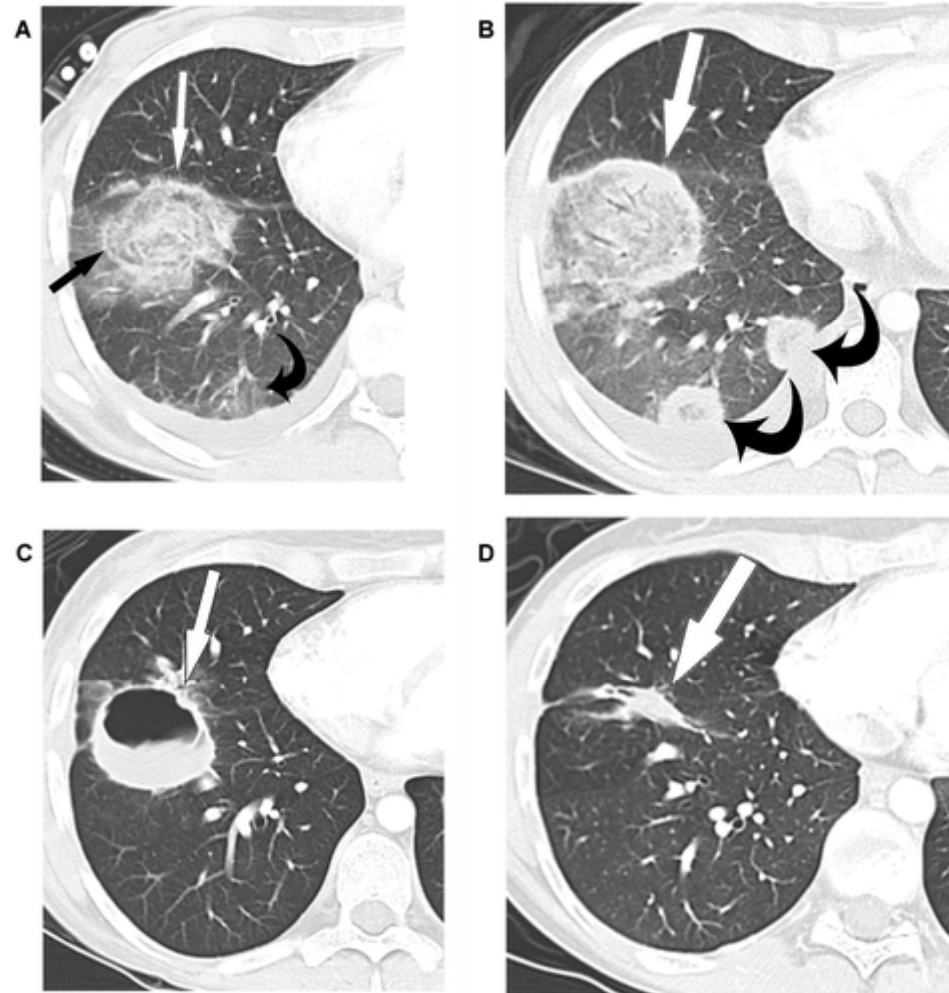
Images from a 24-year-old woman who presented with febrile neutropenia, with recurrence of acute myelogenous leukemia, and graft-versus-host disease 1 year after bone marrow transplantation. A, Contrast enhanced chest CT image obtained 7 days after patient presented with fever and chills, showing focal ground-glass opacity mass surrounded by soft tissue ring (straight arrows), the reversed halo sign. Curved arrow points to nodular ground glass opacity before formation of the sign. Dry cough developed 7 days after this CT image was obtained. B, CT image obtained 10 days after image in panel A, showing better delineation of the reversed halo sign, with increasing wall thickness (straight arrow) and interval formation of the sign around previously seen poorly marginated nodular ground-glass opacities (curved arrows). Results of transthoracic needle biopsy showed numerous fungal hyphae, which, on culture, were confirmed to represent *Zygomycetes* species. C, CT image obtained 2 months after image in panel A, showing interval cavitation of the reversed halo sign mass (arrow) and nodules (not shown). D, Follow-up chest CT image, obtained 2 years after that shown in panel A, showing residual scar in the right lower lobe (arrow).
